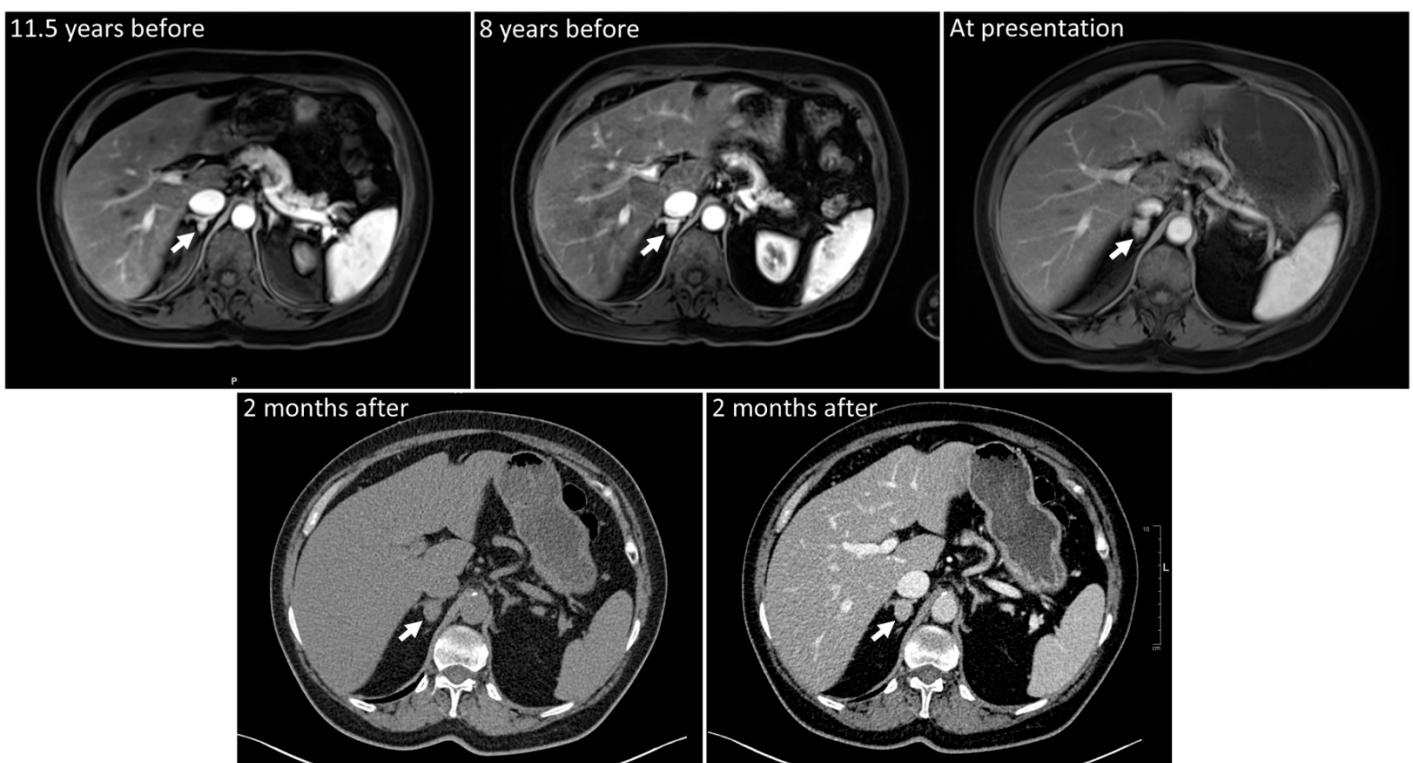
MRI and CT axial images of the adrenal mass. Top, MRI with gadolinium enhancement; bottom, CT without (left) and with contrast (right). Arrows, adrenal mass.
